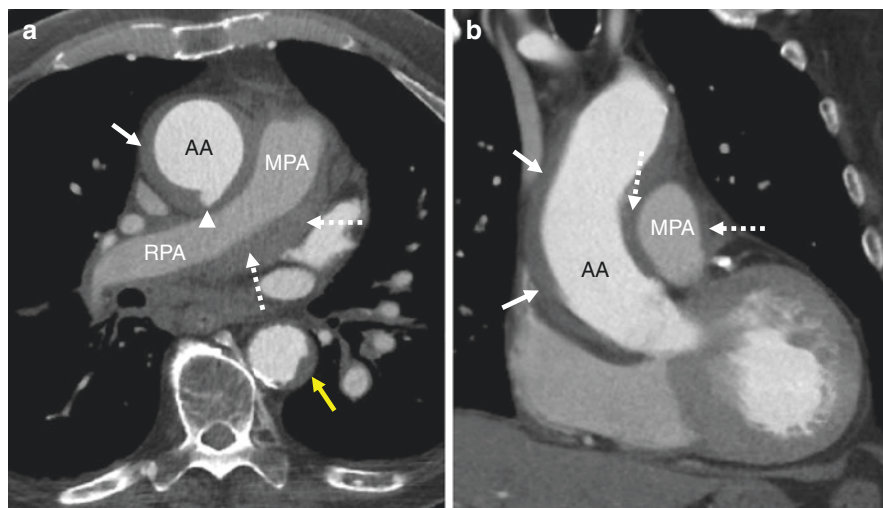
Axial (a) and coronal (b) postcontrast CT images of a 75-year old man with chest pain demonstrating a ruptured type A IMH (white arrows) with an ulcer-like projection in the posterior ascending aorta (arrowhead). Soft tissue density material surrounding the main and right pulmonary arteries (MPA, RPA) represents mediastinal blood tracking into the shared adventitia between the aorta and pulmonary arteries—a ‘shared-sheath’ hematoma (dotted arrows). Note that the irregular mural atheroma in the mid descending aorta (yellow arrow) is slightly lower density than the IMH and lacks its smooth crescentic morphology. AA Ascending aorta
